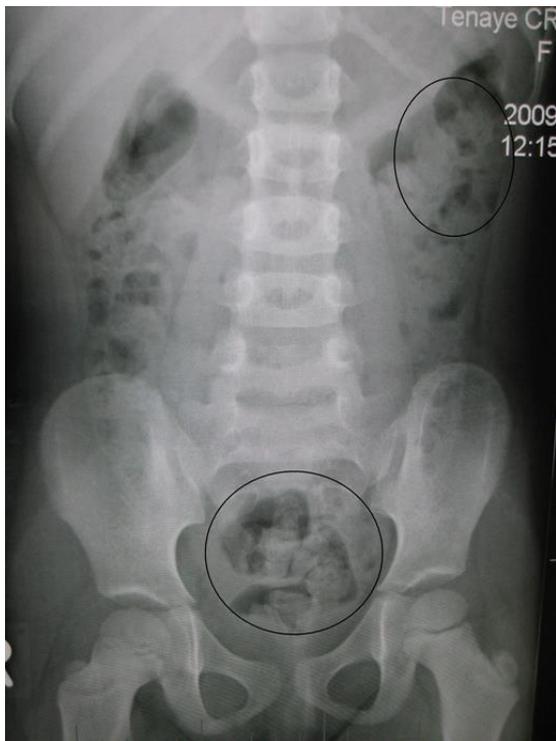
Constipation in a young child as seen on X-ray (circles indicate two areas of fecal material in the large bowel and rectum) (By [James Heilman, MD](#) - Own work, [CC BY 3.0](#))
